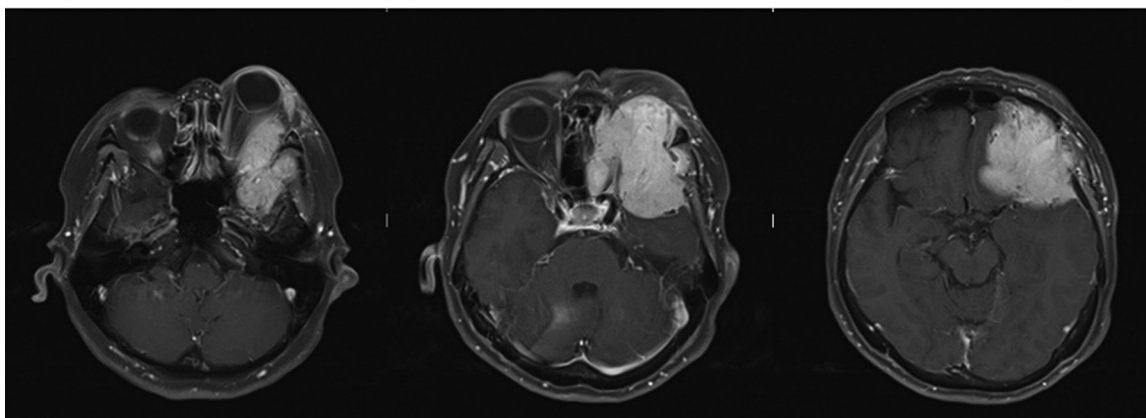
Cranial MRI with Contrast showing the left sphenoorbital tumor.
